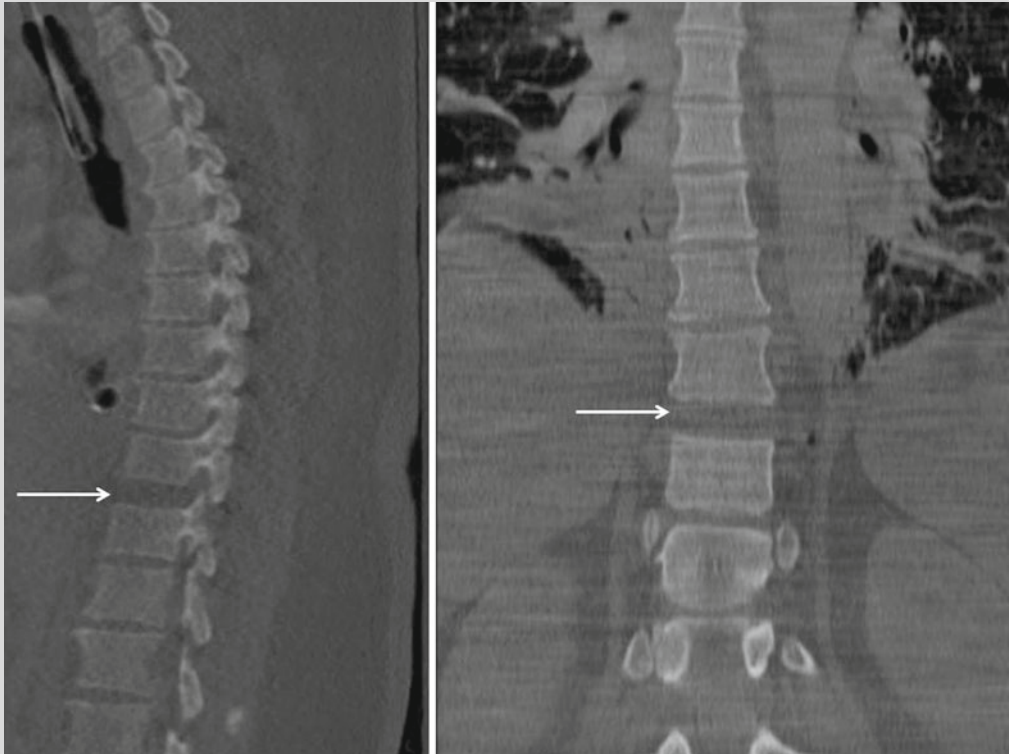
Sagittal and coronal computed tomography (CT) reformations of the thoracic spine. The *arrows* point to the severely injured T9–10 segment. Vertical distraction injury is present resulting in severe spinal instability
